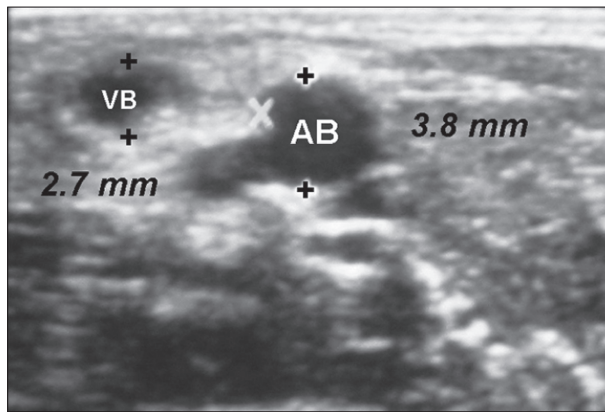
Initial color duplex sonography examination of the diameter of the brachial artery (3.8 mm) and the basilic vein (2.7 mm) in the region of the distal left arm
